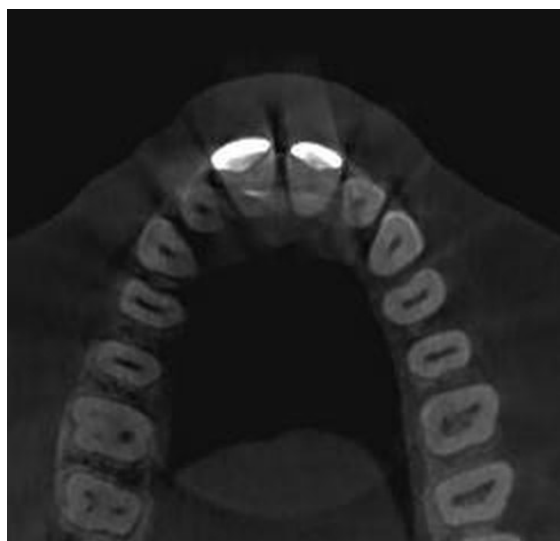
Figure Axial image of maxilla showing various CBCT artifacts associated with metallic restoration in teeth 11 and 21.
